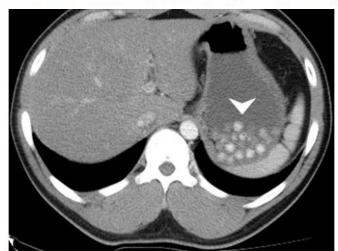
Axial computed tomography (CT) demonstrated accumulation of small round hyperdensities in a distended saccular structure in the upper abdomen. The tapioca particles exhibited a CT density between 46 - 221 Hounsfield units, and few of them could be traced down in the duodenum and jejunum.
